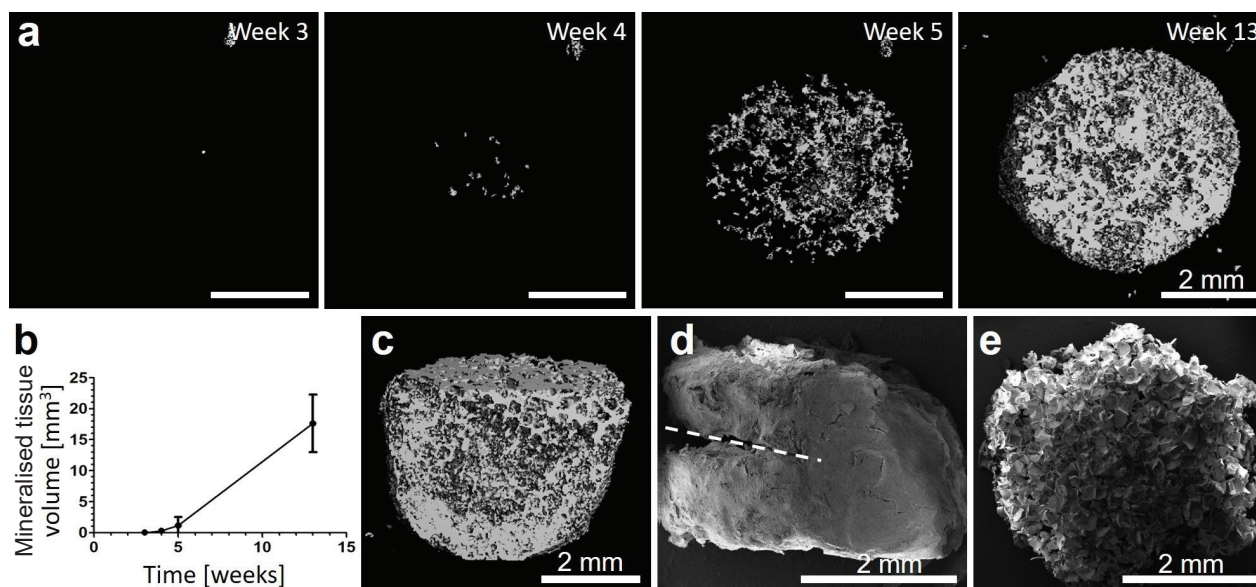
Formation of a mineralised matrix by osteoblasts on 3D SF scaffolds. (a) Non-mineralised SF scaffolds are not visible on μ CT images. Mineralised matrix became detectable after 4 weeks of culture and increased in volume over time. Images are top-down views. Scale bars are 2 mm. (b) The mineralised tissue volume of the constructs continuously increased over time. (c) An inclined view on a digital cross-section of a μ CT image shows the mineralised matrix distribution within a construct at week 13. (d) SEM example image of an SF scaffold after 9 weeks of osteoblast culture, showing that tissue formation completely concealed the pores of the SF scaffold, necessitating incising the construct to seed monocytes inside. A dashed line shows where the construct was incised for seeding. (e) SEM control image of an SF scaffold without any cells.
